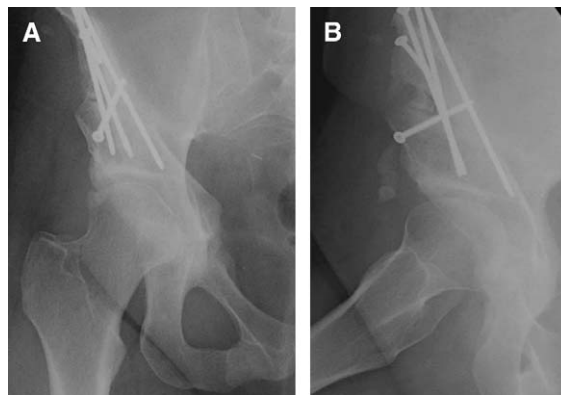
Periacetabular osteotomy treatment of DDH. (A,B) This postoperative set of radiographs anteroposterior and lateral, respectively) shows a periacetabular osteotomy that results in appropriate coverage of the femoral head both laterally and anteriorly. This is the patient whose preoperative images are shown in Fig. 12.
